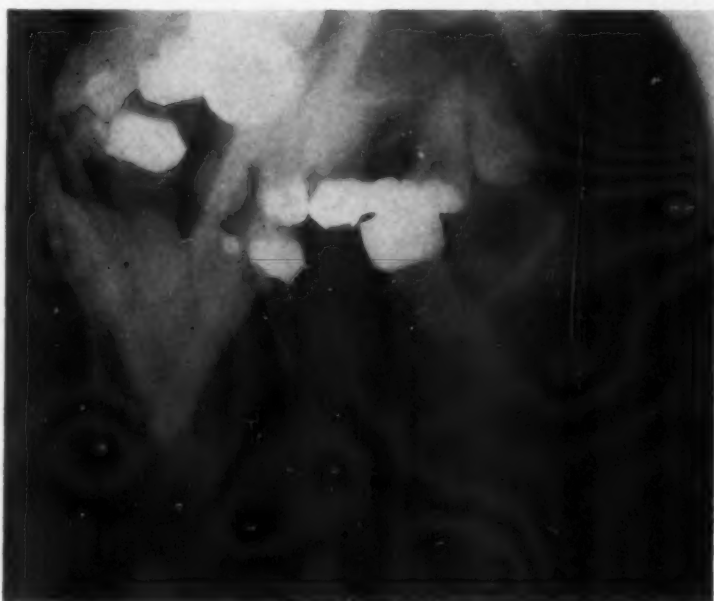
X-ray of Case 1, after first stage, showing depth of drill cuts outlining bone to be removed at final stage.
